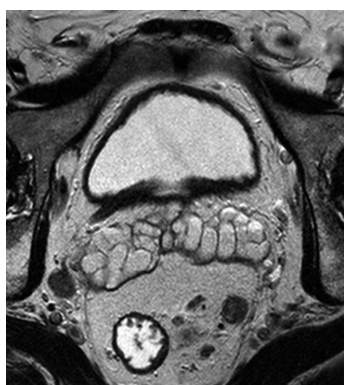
Magnetic resonance imaging of the T3 rectal cancer showing lymph node involvement.
